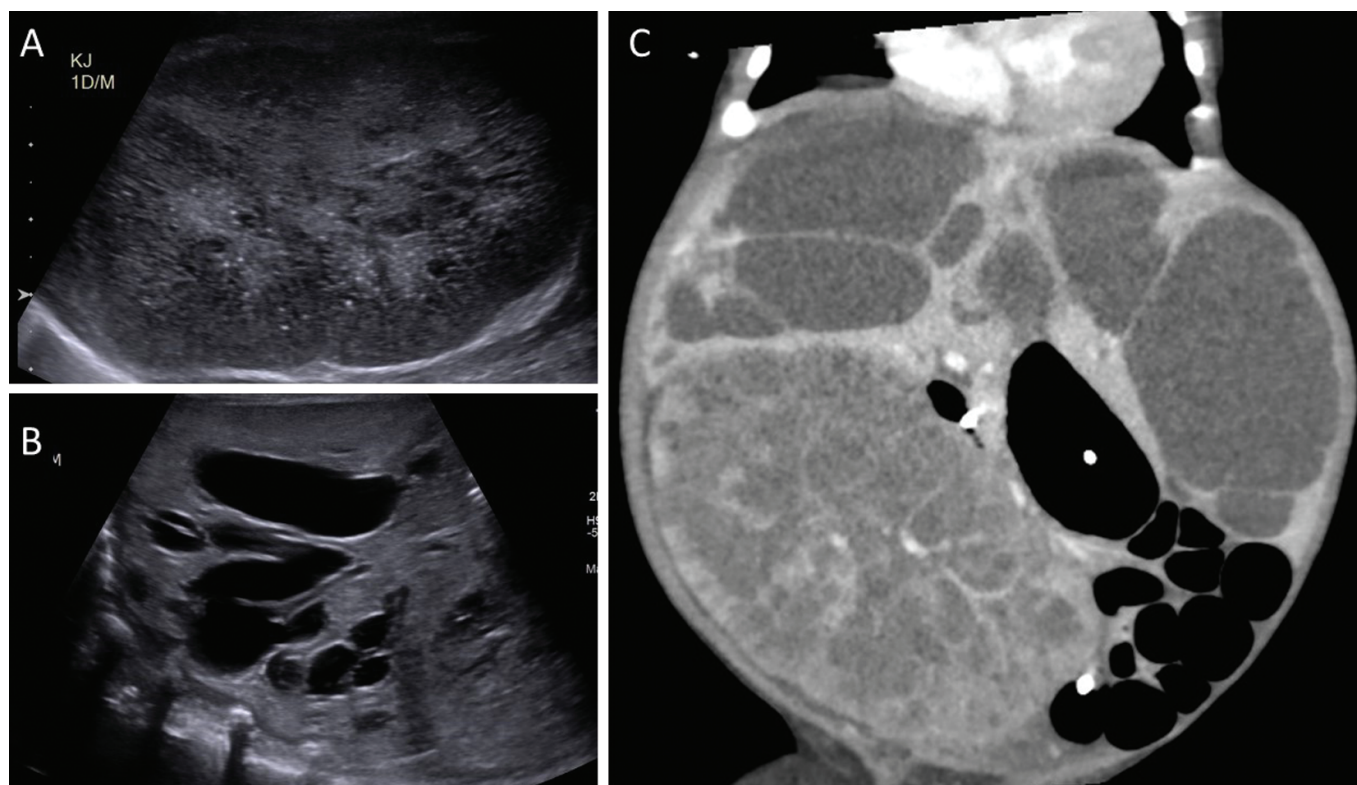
A, renal ultrasound of newborn child with ARPKD demonstrates a markedly enlarged kidney measuring 7.5 cm with cylindrical cysts in medulla and cortex, representing ectatic collecting ducts. B, liver ultrasound reveals multiple cystic spaces of varying sizes, likely dilated intrahepatic bile ducts. C, CT of abdomen and pelvis with contrast of same child at 3 months old. Liver and right kidney (13 cm) have enlarged considerably since birth, causing significant abdominal distention and stomach and bowel compression, as well as upward displacement of diaphragm with low lung volumes. Left kidney is surgically absent.
